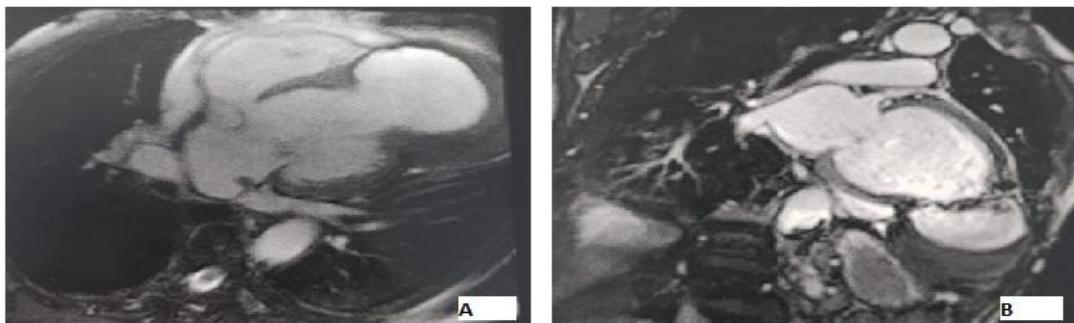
(A and B): Magnetic resonance imaging sections showing left ventricular aneurysm.
